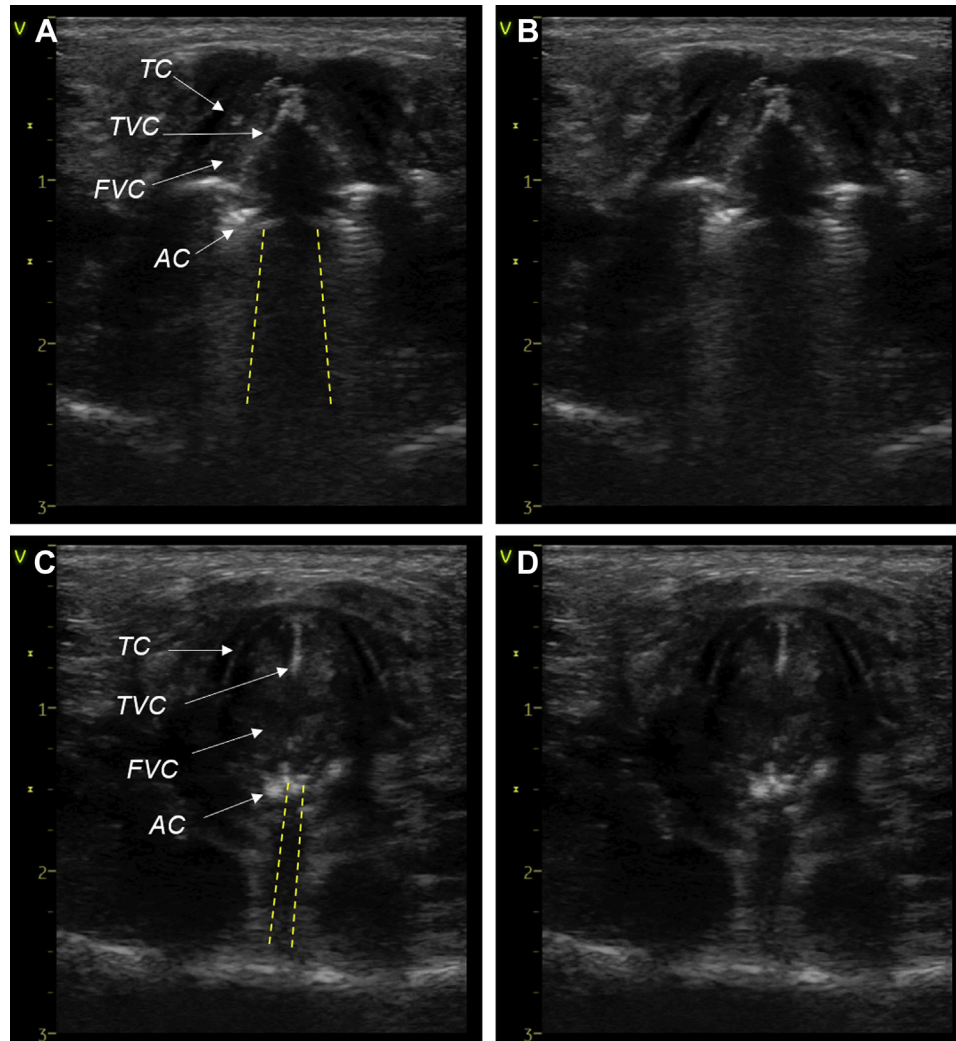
Airway ultrasound findings in laryngomalacia. Inspiratory collapse of arytenoids and narrowing of glottic opening during vigorous crying is clearly observed. A and B, Transverse view at the level of the thyroid cartilage during expiration. C and D, Transverse view at the level of the thyroid cartilage during inspiration. TC, thyroid cartilage; TVC, true vocal cord; FVC, false vocal cord; AC, arytenoid cartilage. The dashed lines indicate the width of the air column artifact caused by glottic opening. Note the near-complete glottic closure on inspiration.
